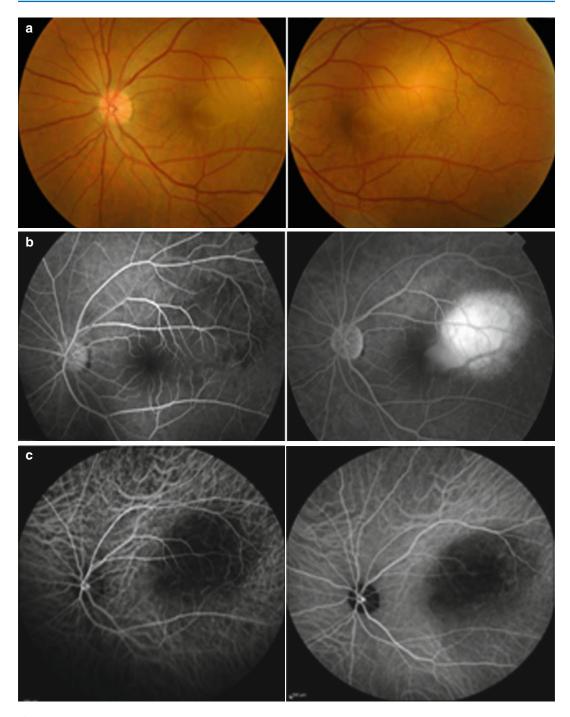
Left eye of a 37-year-old man with strongly positive tuberculin skin test (18 mm induration). Visual acuity was measured by counting fingers at 3 ft. Fundus photographs shows subretinal amelanotic choroidal mass with exudative retinal detachment (a). Fluorescein angiography shows that the lesion is hypofluorescent in the early phase and hyperfluorescent in the late phase (b). Indocyanine green angiography shows that the lesion is hypofluorescent throughout (c). Optical coherence tomography shows exudative retinal detachment (d). Ultrasonography shows a solid elevated mass lesion on B-scan and a low internal reflectivity on A-scan (e). Two months after starting antituberculous therapy and systemic corticosteroids. Visual acuity improved to 20/25. Fundus photography shows resolution of the granuloma and chorioretinal scar. Optical coherence tomography displays resolution of exudative retinal detachment (f)
